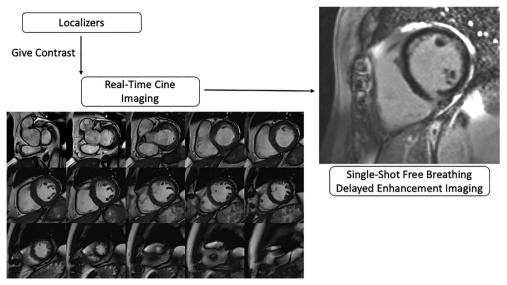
Rapid Cardiac MR imaging protocol for scar evaluation. Contrast is administered after confirming patient centering. Conventional breath-held segmented cine imaging is replaced with real-time cine sequences performed under either suspended respiration or free breathing. Myocardial delayed enhancement can be performed with single shot imaging techniques under suspended respiration or free breathing. The entire study can be completed in 15 minutes with excellent image quality in dyspnea and arrhythmia.
